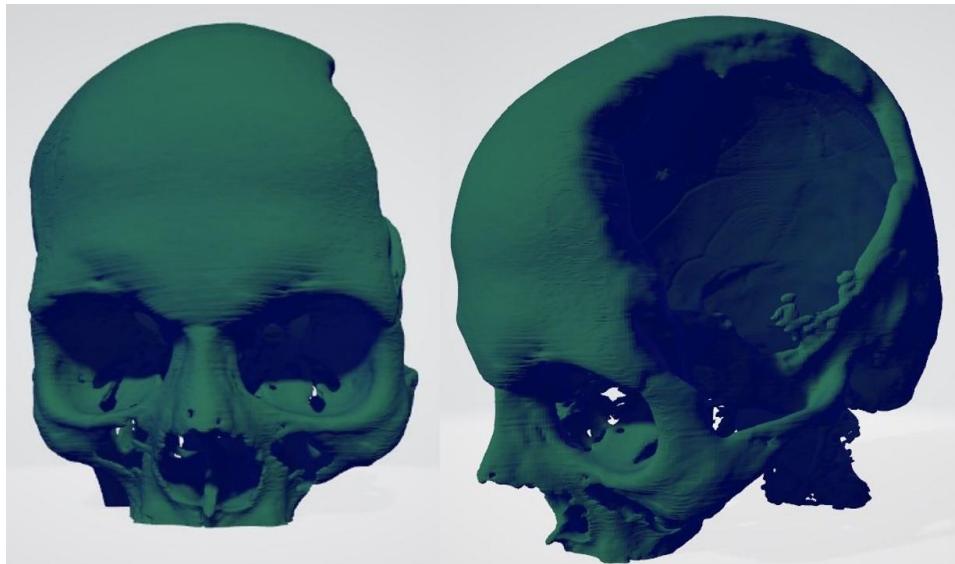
Generation of the 3-D image of the patient's skull using CT-SCAN
